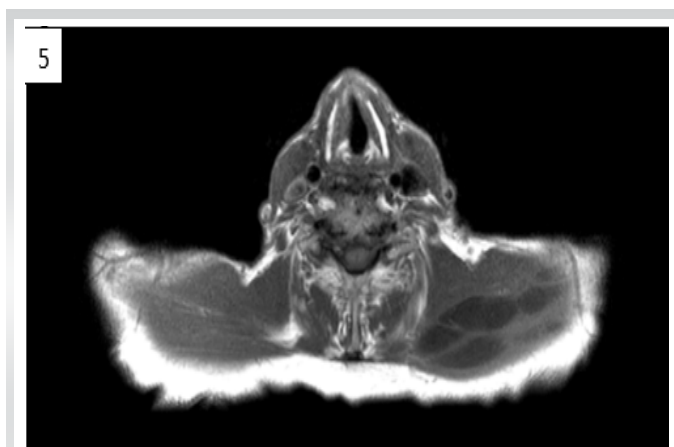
MRI: axial view.
